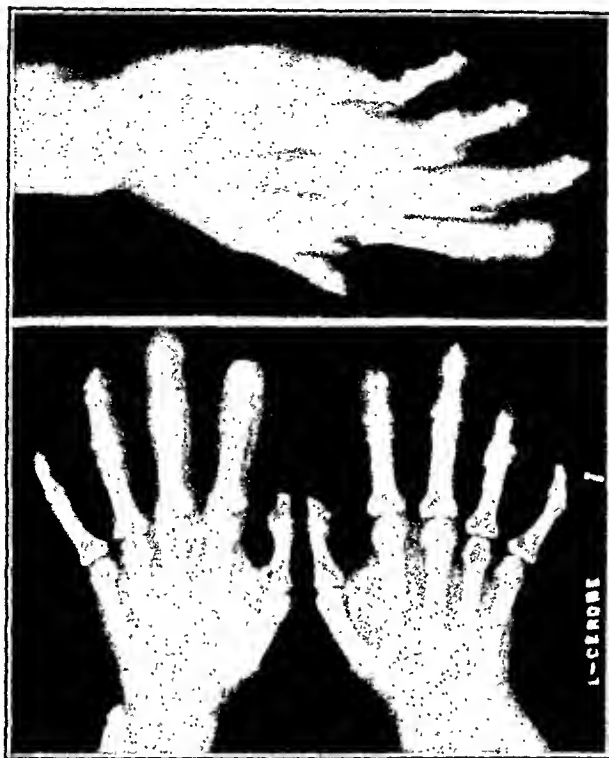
Patient L. C., x-ray films of the right hand showing atrophy of the terminal phalanges and calcinosis of the middle metacarpal joint of the fourth finger.
